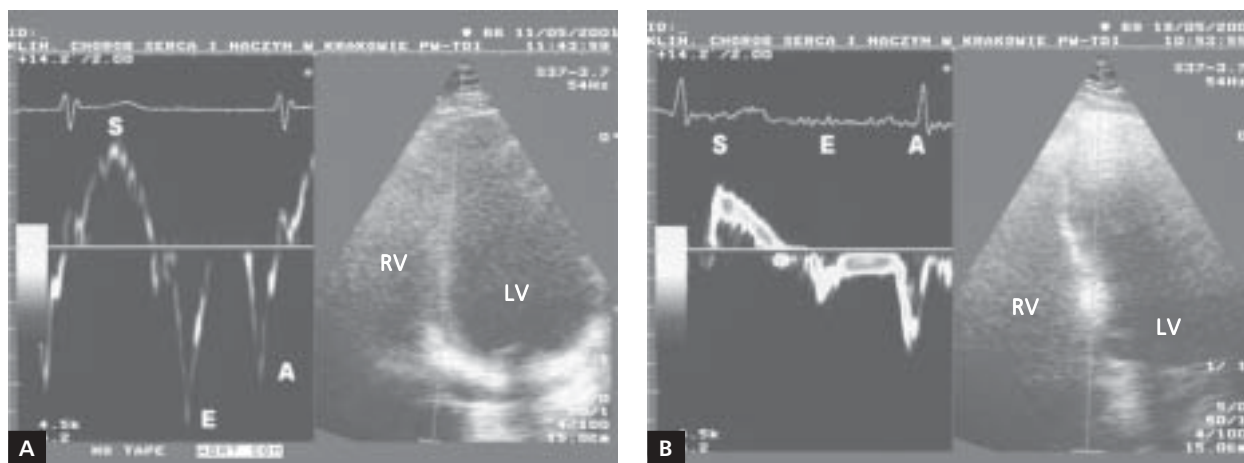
Tissue Doppler echocardiography recording in a healthy person (A) and in a systemic sclerosis (SSc) patient (B). Note the systolic (S) wave, early diastolic (E) wave and end diastolic (A) wave. In the SSc patient, E velocity is significantly decreased; LV — left ventricle; RV — right ventricle
